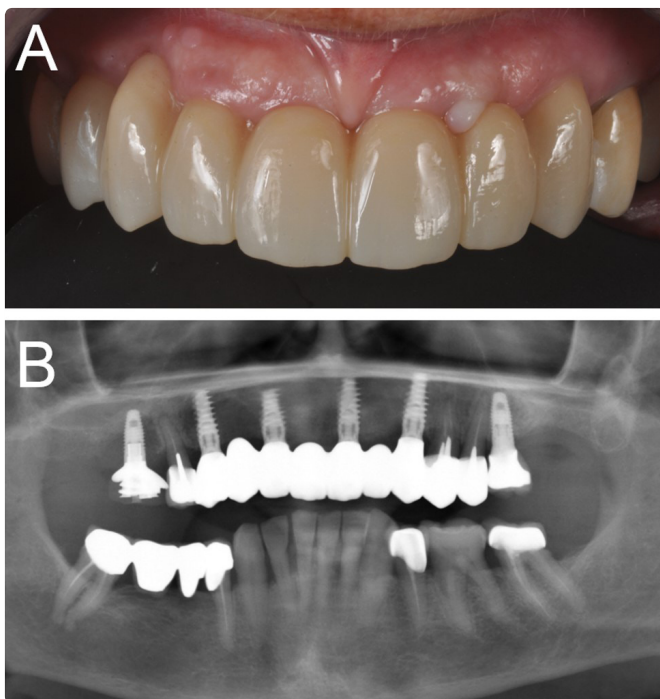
Delivery of the final screw-retained fixed PP. The same CAD project of the milled prototype is duplicated in zirconia. (A) Clinical view. (B) Panoramic radiograph.
